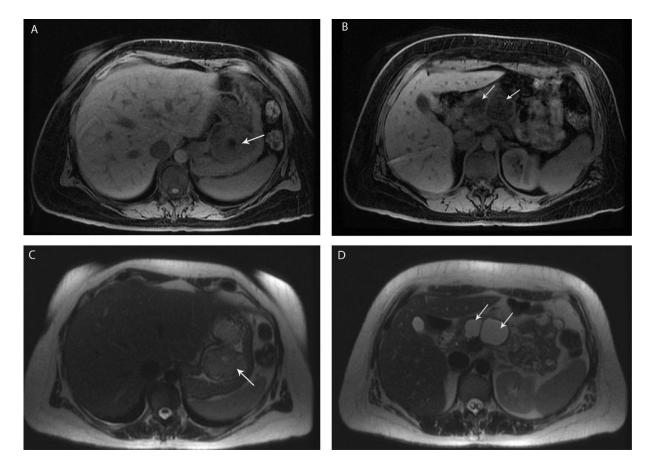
Axial Water LAVA-Flex MRI Abdomen w/o contrast showing ulcerated gastric body mass (A, white arrow) and cystic dilations in pancreas (B, white arrows). Axial SSFSE MRI Abdomen w/o contrast showing gastric body mass (C, white arrow) and cystic dilations in pancreas (D, white arrows)
